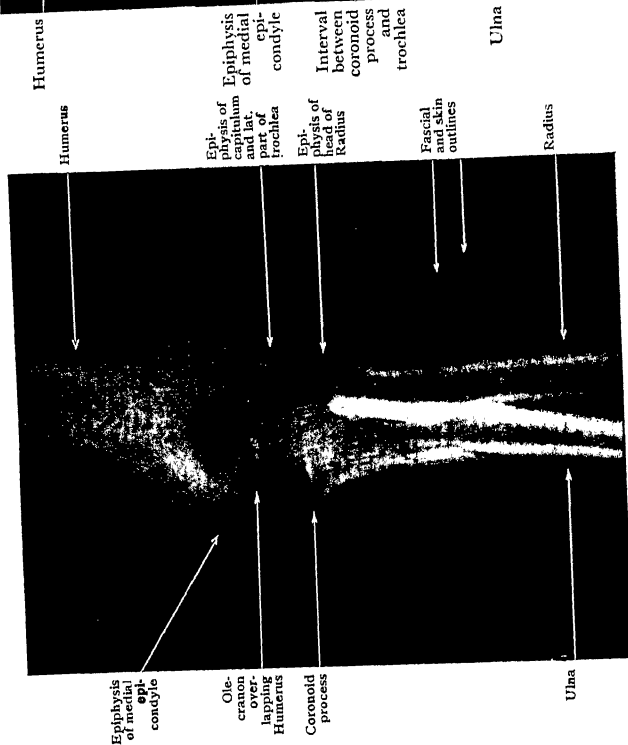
Radiograph of Elbow of boy aged 7. Note that centre for capitulum forms part of the trochlea, and that the other trochlear centre and the lateral epicondyle centre have not yet appeared. For later stages of development of the epiphyses, see Figs. 85, 87.
